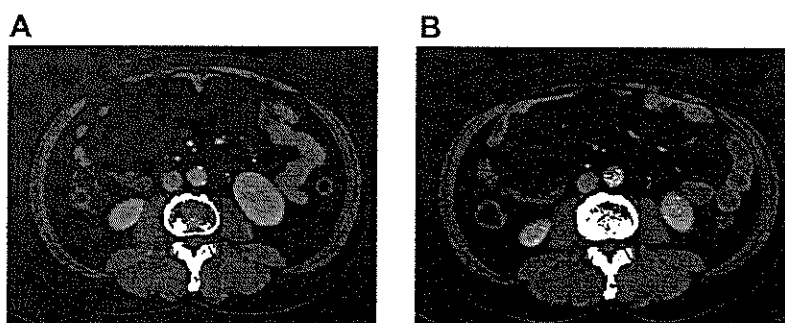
Measurement of bilateral psoas muscle areas. Bilateral psoas muscle areas were measured by manual tracing computed tomography (CT) images (area delineated) at the third lumbar vertebrae level on preoperative and postoperative scans. (A) preoperative CT; (B) postoperative CT.
